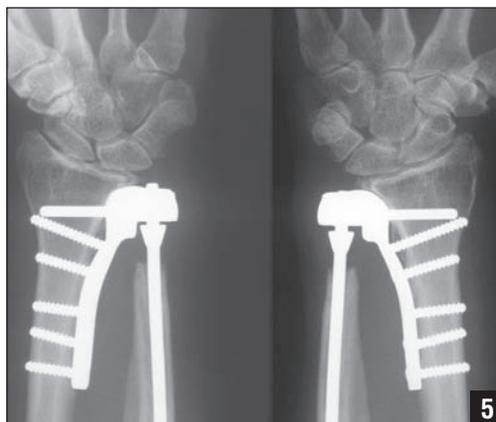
Radiograph at 24 months after reconstruction of the distal radioulnar joint with hemiarthroplasty¹⁰⁶ in painful arthritis of the distal radioulnar joint following an extrarticular distal radius malunion. Figure courtesy of the Christine M. Kleinert Institute for Hand and Microsurgery. Figure 5: The result of a total distal radioulnar joint arthroplasty using semi-constrained modular, ultra-high molecular weight polyethylene prosthesis in pronation (left) and supination (right). Prior to the prosthetic replacement, the patient had undergone excision of the distal ulna and presented with a painful wrist and forearm motion 2 years postoperatively. Follow-up 3 years after prosthetic replacement revealed full prono-supination of the forearm, as well as pain-free range of motion of the wrist and elbow. The patient returned to his previous job 4 months postoperatively. Figure courtesy of the Christine M. Kleinert Institute for Hand and Microsurgery.
